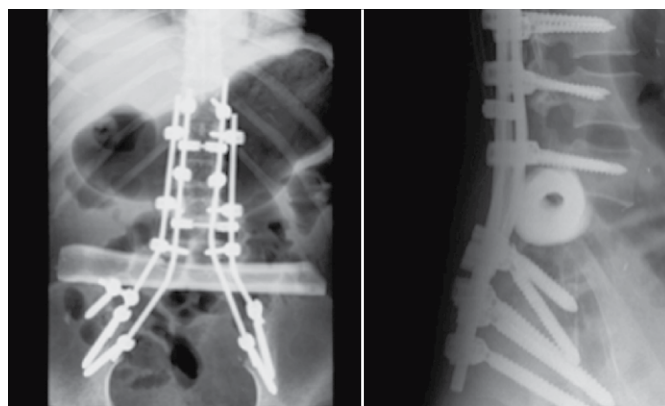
Postoperative radiographs showing compression of the graft with double bars fixation.
